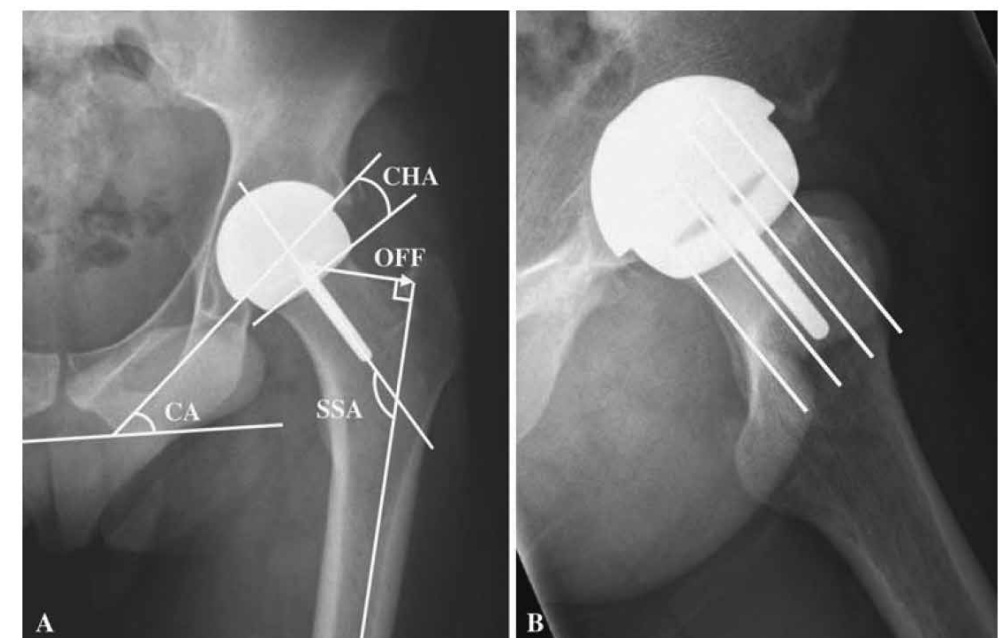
Example of radiographic measurements on the postoperative X-ray from the first cohort. A Anteroposterior radiograph with the CA, SSA, CHA and stem position in the frontal plane. B Lateral radiograph showing stem position in the middle-third of the collum.
